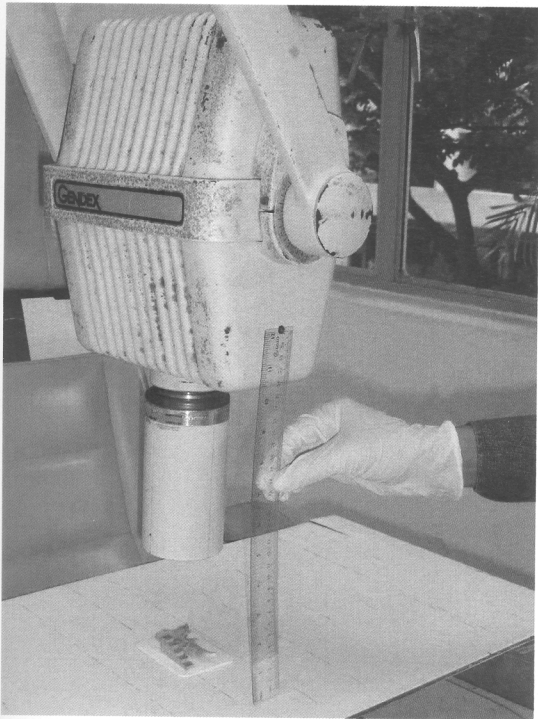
The lateral film of hemimandible, a ruler was used to keep the same distance between the X-ray tube and the film. An aluminum step-wedge used The X-ray machine (Gendex, Illinois, USA).
